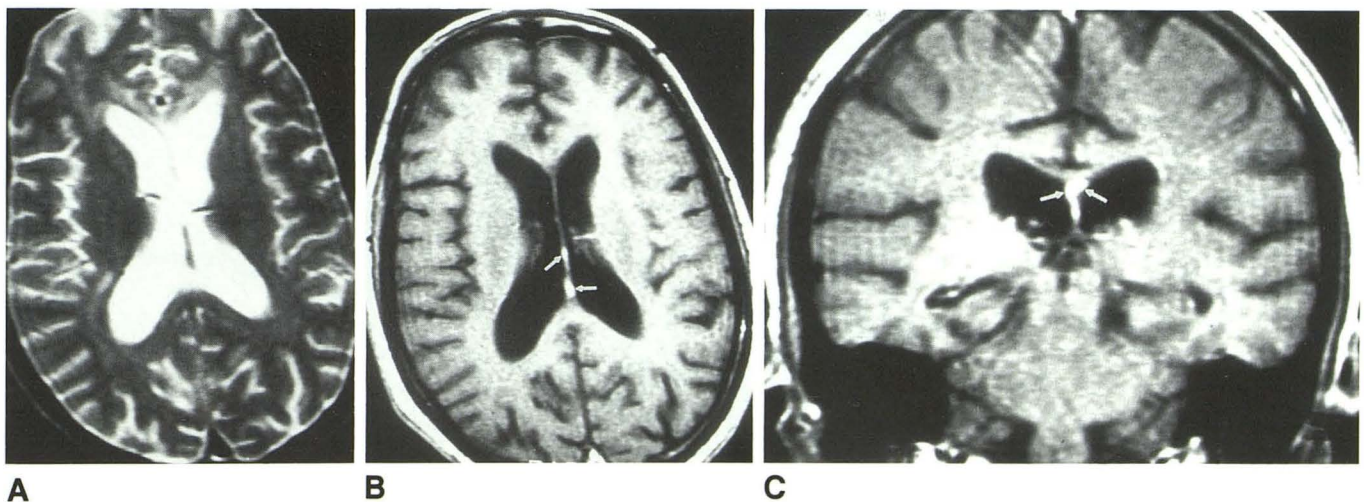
Patient with rapidly worsening dementia. A, It is difficult to identify a mass or surrounding edema in the posterior fornix on the axial T2-weighted (2000/80) image due to the high signal CSF in the dilated lateral ventricles. On the postcontrast T1-weighted (600/20) axial (B) and coronal (C) images, an enhancing mass in the posterior fornix is identified (*arrows*). No mass was seen in this region on the unenhanced T1-weighted images (not shown). The patient did not improve on empiric antitoxoplasmosis therapy given to treat this and several other parenchymal lesions, and at autopsy was shown to have CNS lymphoma.
